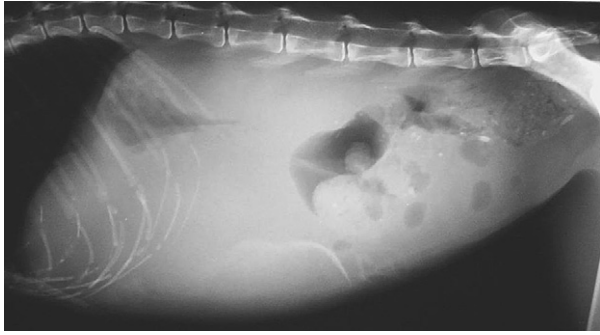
Right lateral abdominal radiograph showing reduced contrast throughout the abdomen which is obscuring the normal abdominal organs. This is likely to be a consequence of poor body condition with a lack of abdominal fat, possibly in association with mild ascites. Displacement of the gastric axis dorsally and of the intestines caudally is apparent, suggestive of a mid-cranial abdominal mass.
